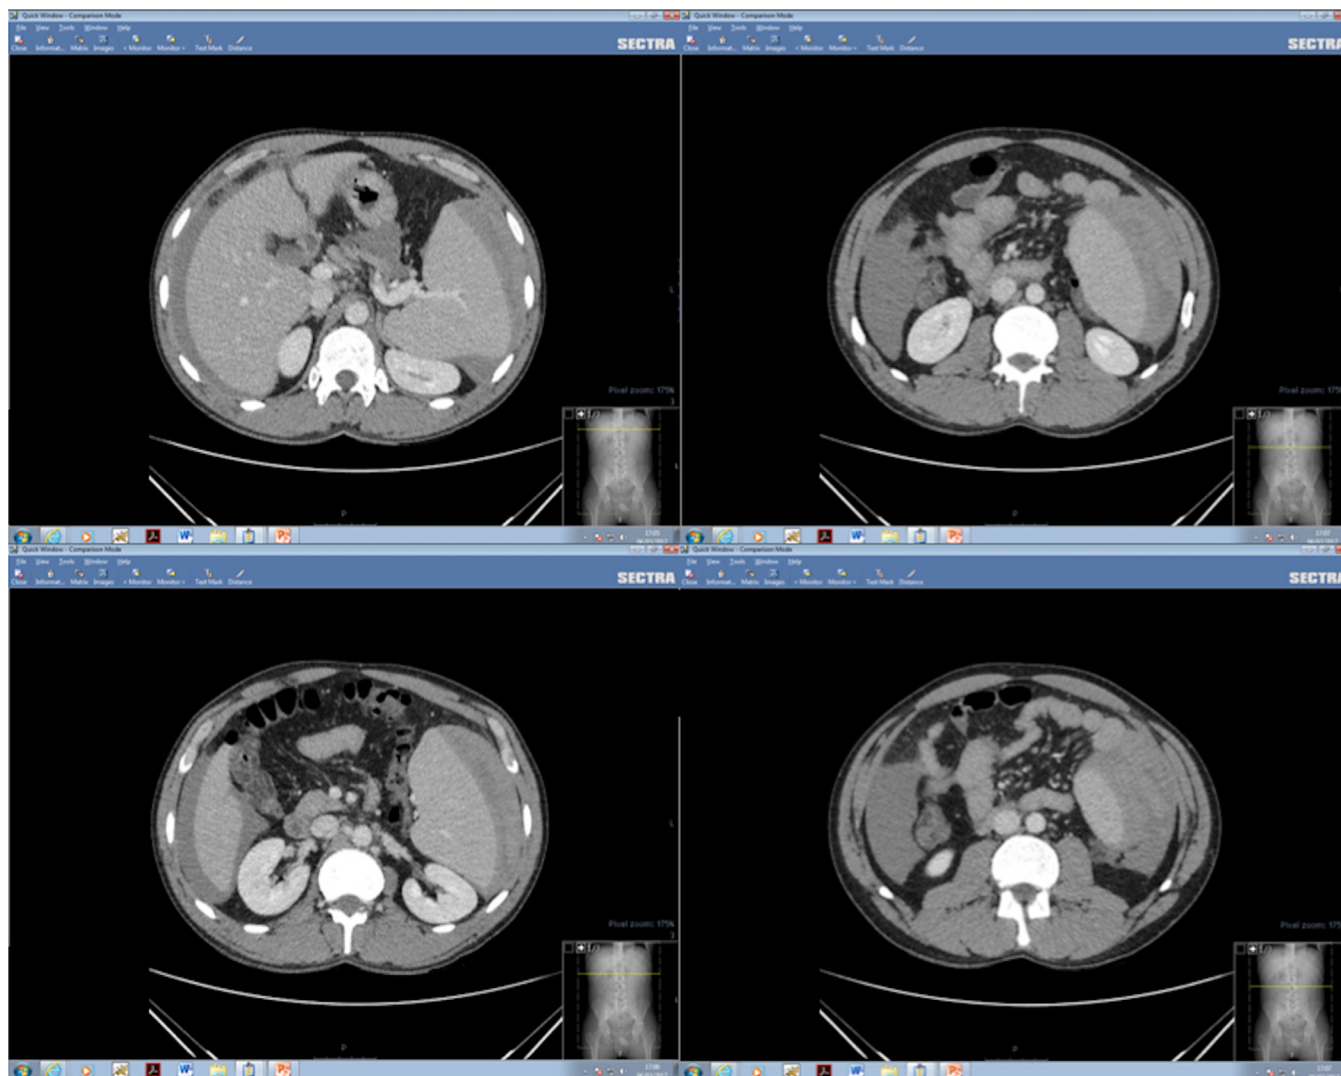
CT abdomen (axial) demonstrating sub-capsular splenic haematoma.
